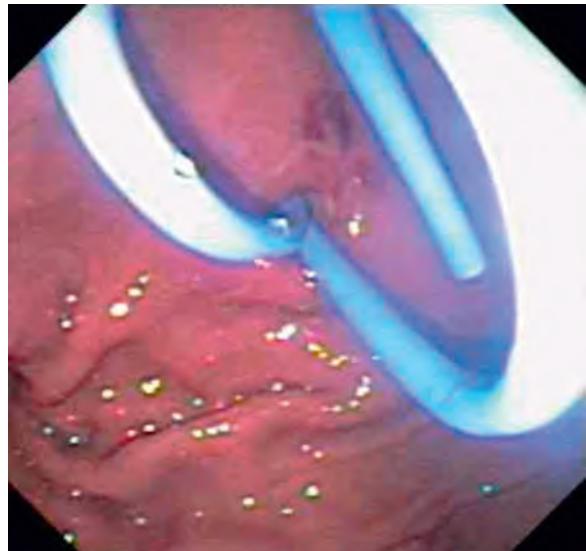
No bulge, but endoscopic presence of gastric varices in a patient with pseudocyst. Endoscopic ultrasound-guided pseudocyst drainage can still safely be performed.
